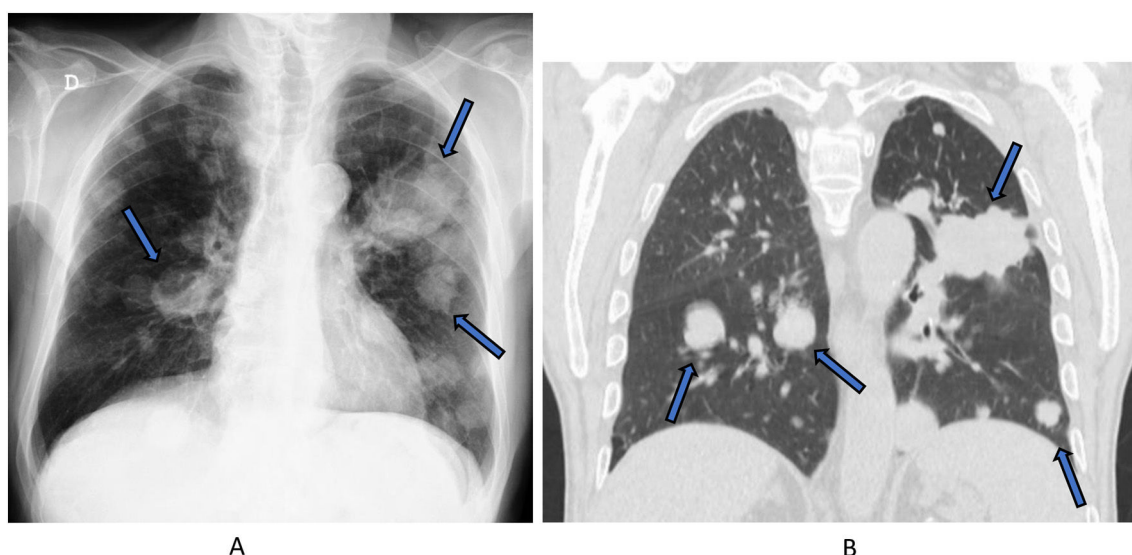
Pulmonary metastasis on chest X-ray and CT-Scan.
